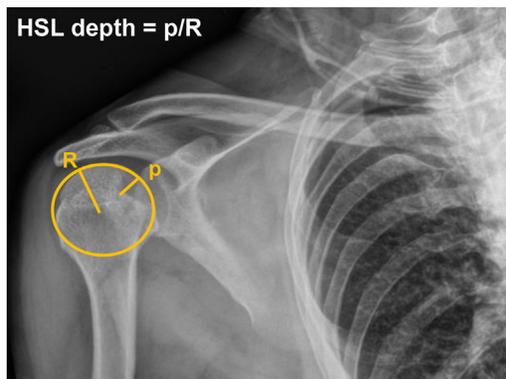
An AP plain film of a right shoulder with a large Hill–Sachs lesion (HSL) demonstrating a quantitative method for measuring the HSL depth index, based on the ratio of the maximum depth of the notch defect (p) in internal rotation and the radius of the humeral head (R).
